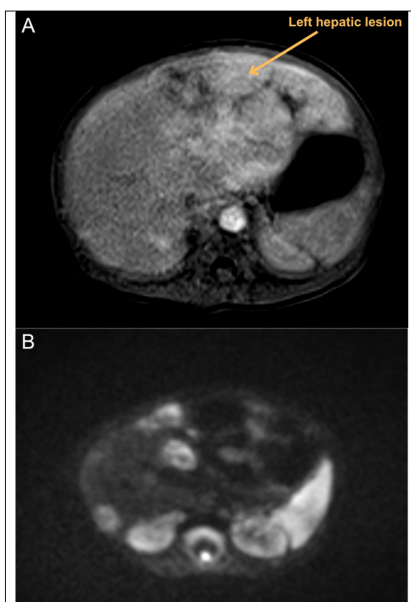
Postnatal MRI of congenital hepatic haemangiomas.
